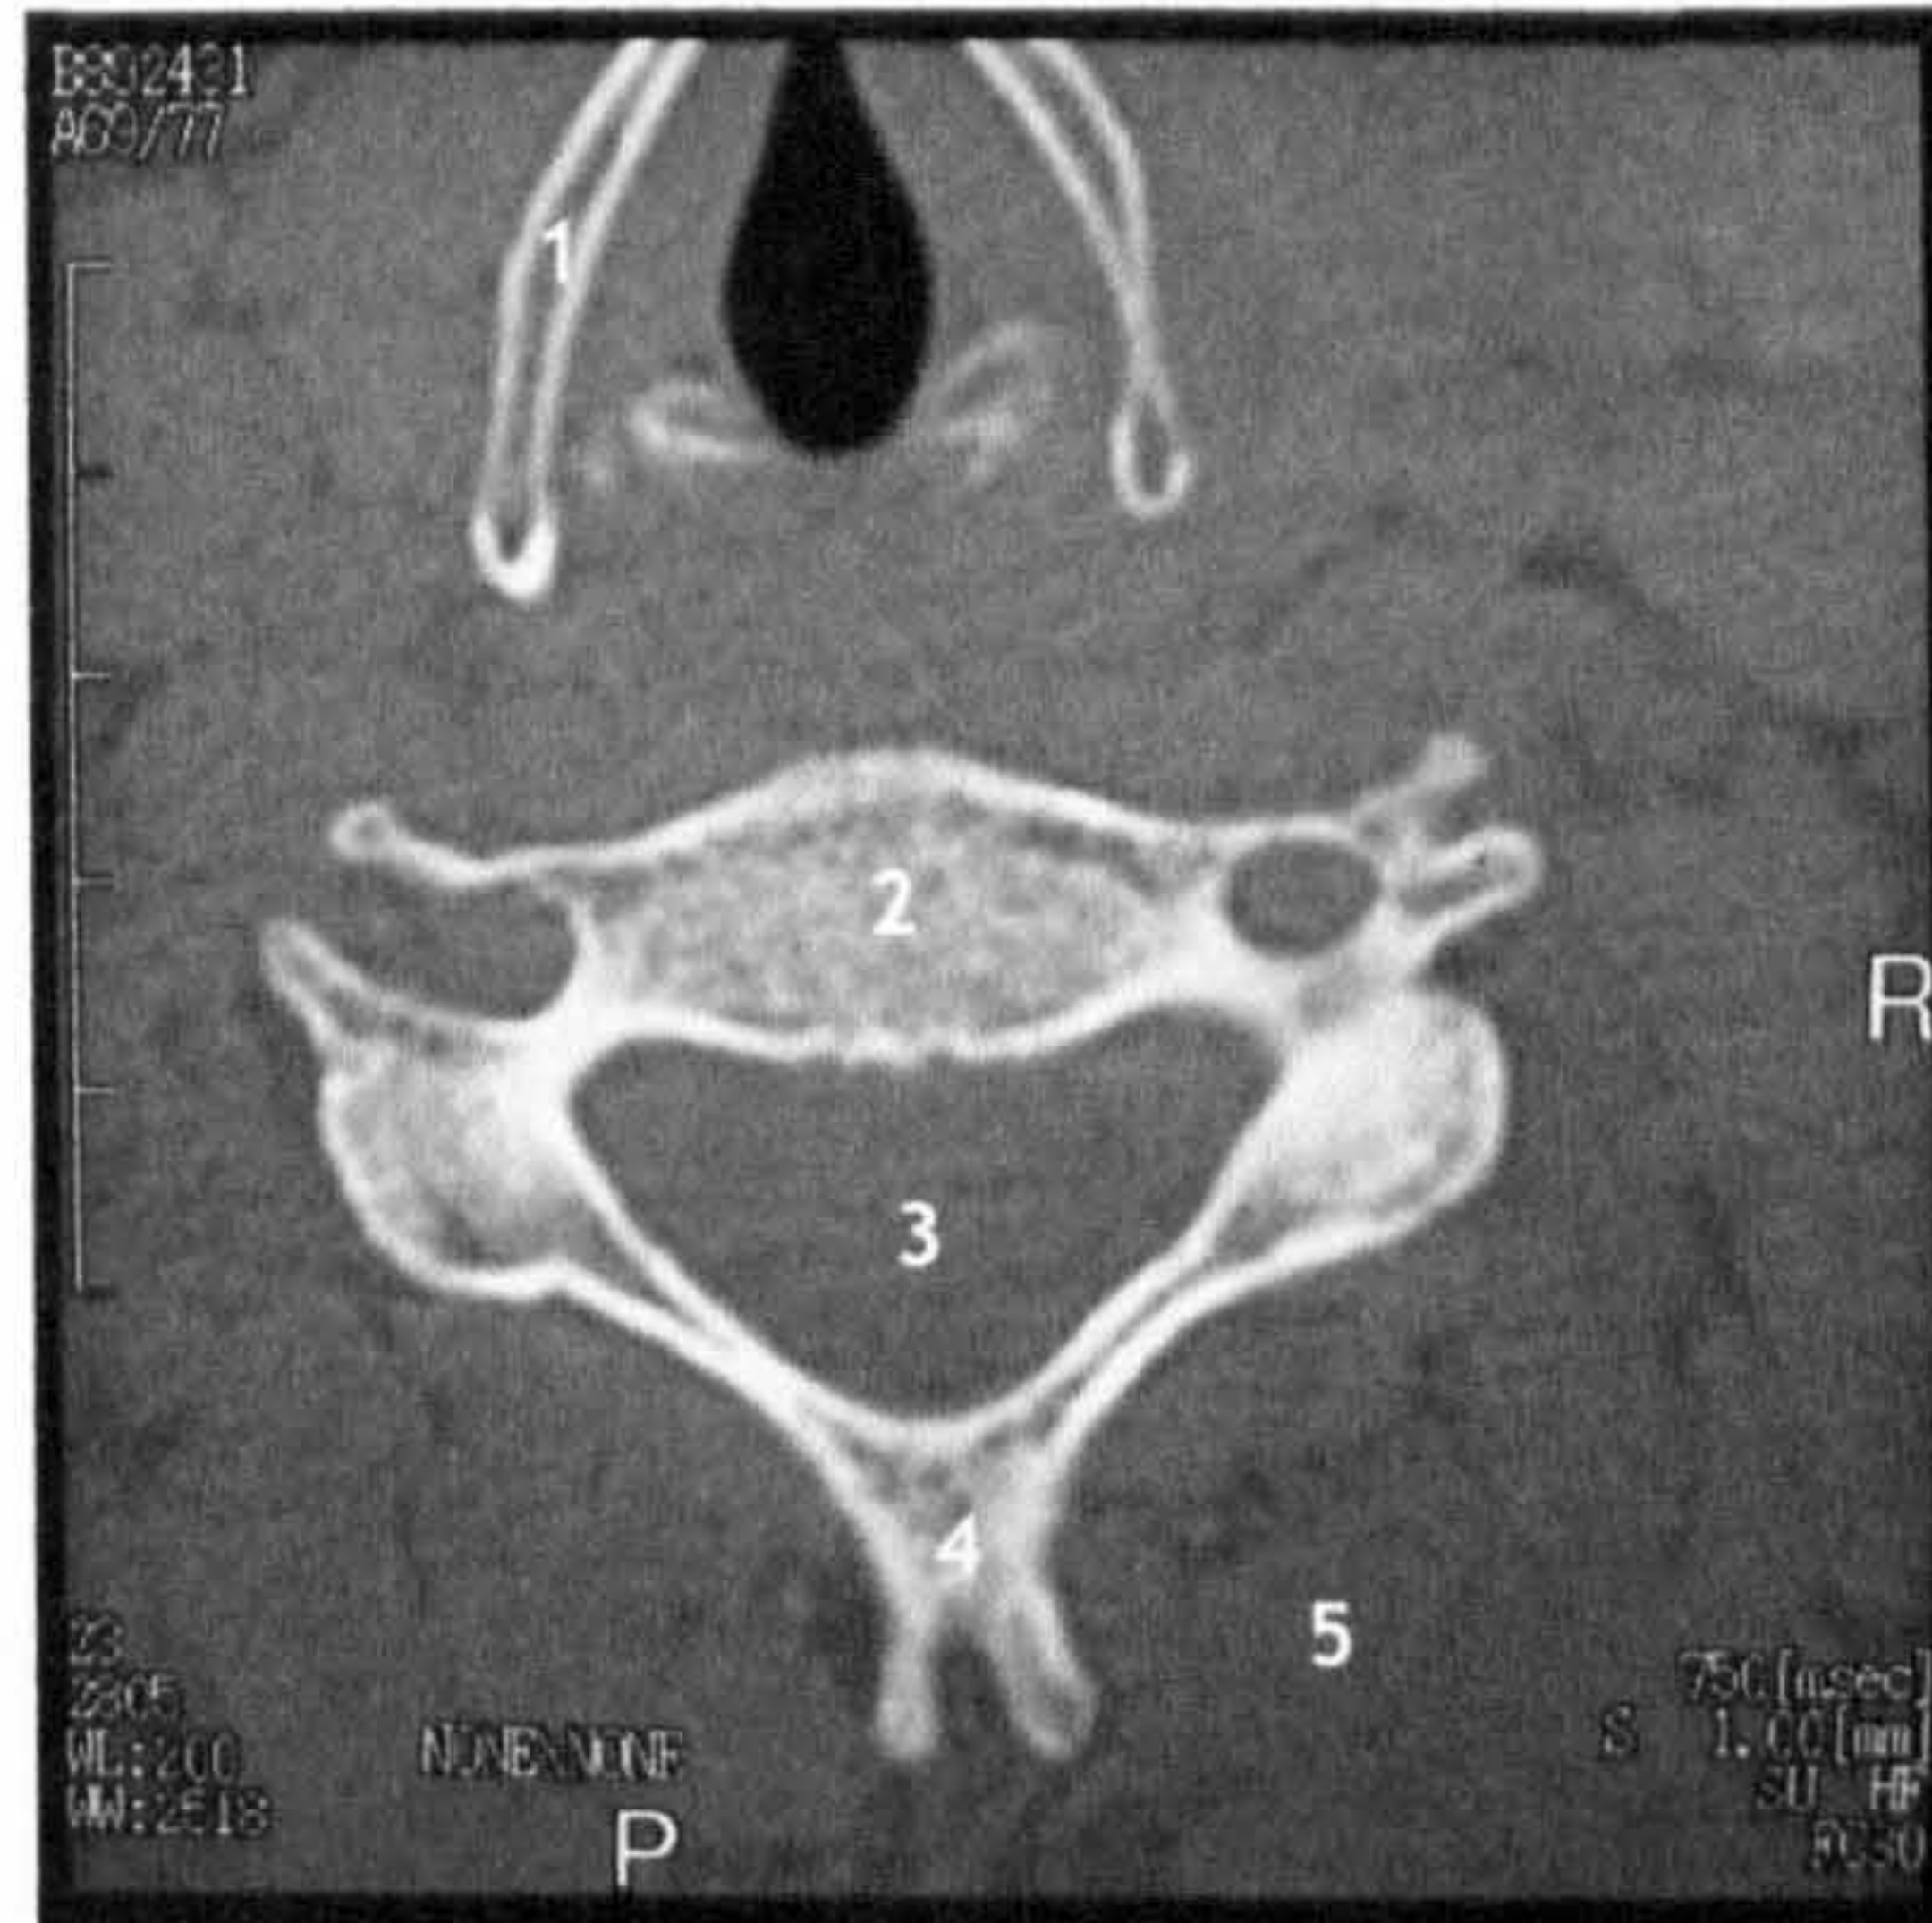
Computed Tomography image of the neck
